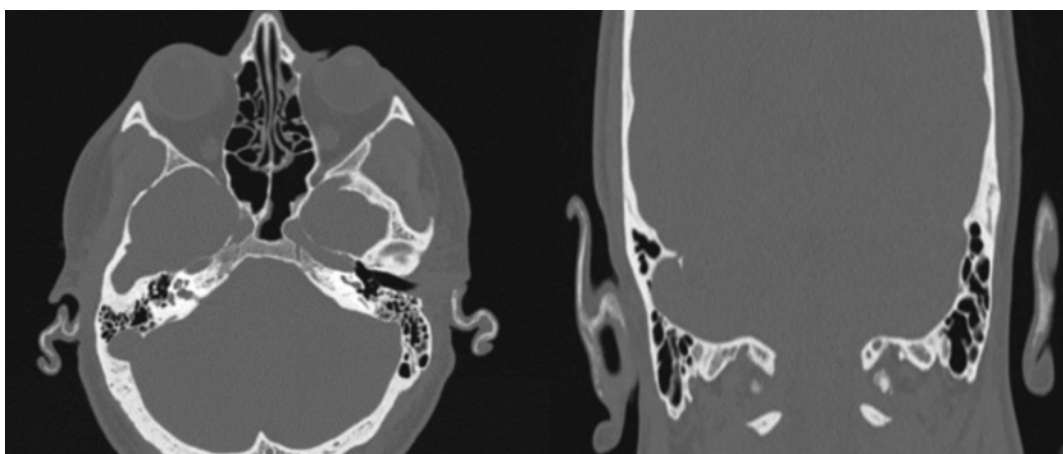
Skull CT showing bilateral auricular cartilage hyperdensities compatible with calcifications.
